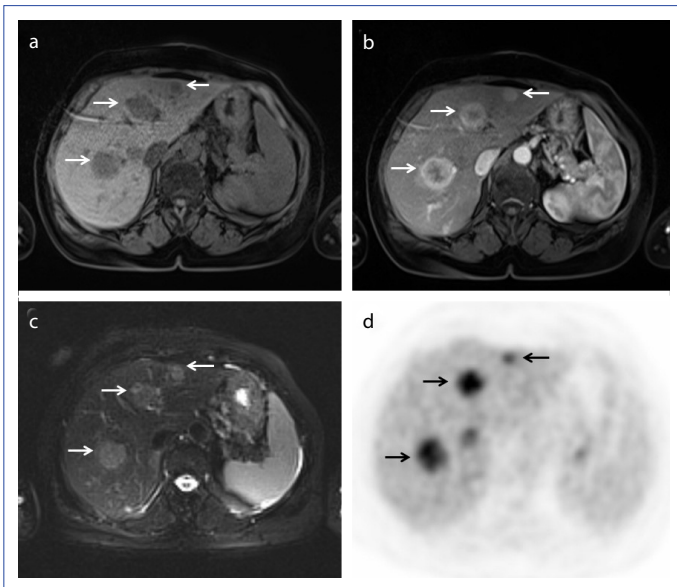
to 3 are representative MRI and PET-CT images.
